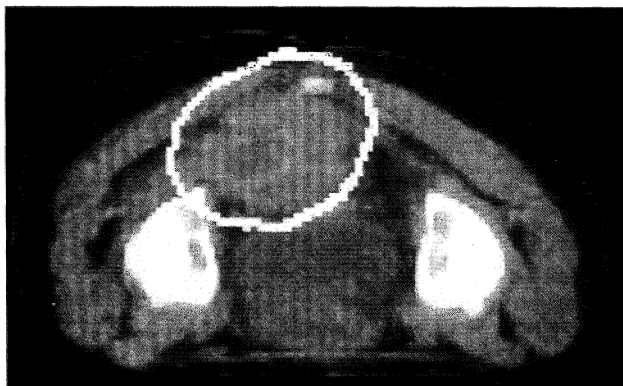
CT-section of a patient with a target volume in the pelvic region (manual segmentation of the target volume).
